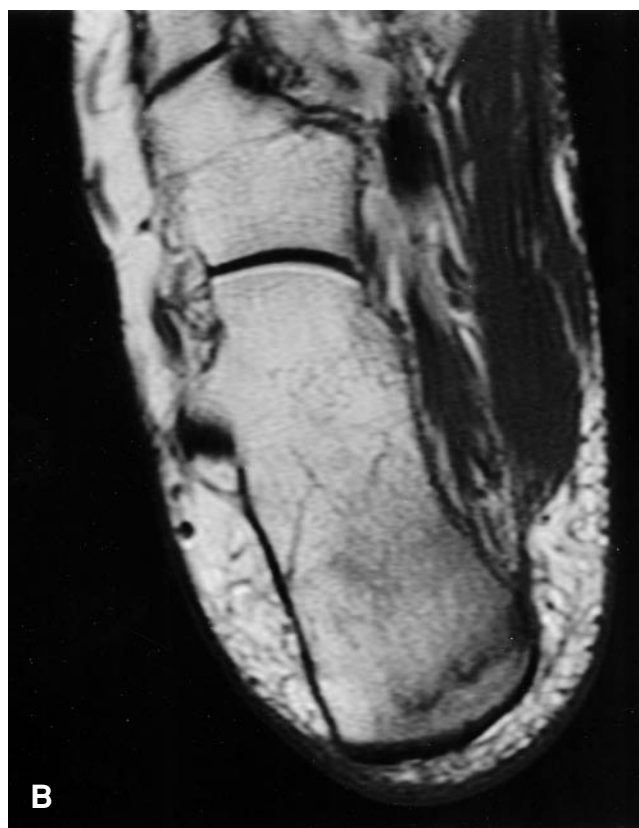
Plain radiograph and magnetic resonance imaging (MRI) in a 69-year-old woman with an insufficiency fracture of the calcaneus. A. Lateral plain radiograph of the ankle: normal. B. Axial T1-weighted images show a linear fracture of low signal intensity surrounded by marrow edema. C. Sagittal T2-weighted fast SE MRI shows an irregular area of high signal intensity in the calcaneus.
